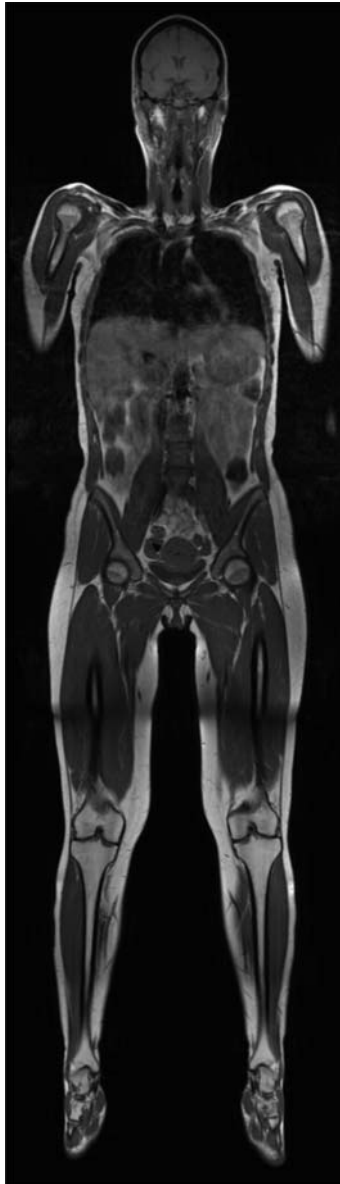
Native whole-body MRI in a patient with asymptomatic multiple myeloma. Since the longitudinal field of view of clinical MRI scanners is typically 40–50 cm, image stacks are obtained stepwise, as the couch is advanced into the scanner, and then “stitched” together to generate, for example, coronal T1-weighted images as in this example. This patient has a typical, diffuse infiltration pattern with hypointensity of the bone marrow (owing to the replacement of fat by cell-dense tissue) in the vertebrae, the pelvis, the humeri and femora, sparing the epiphyses.
